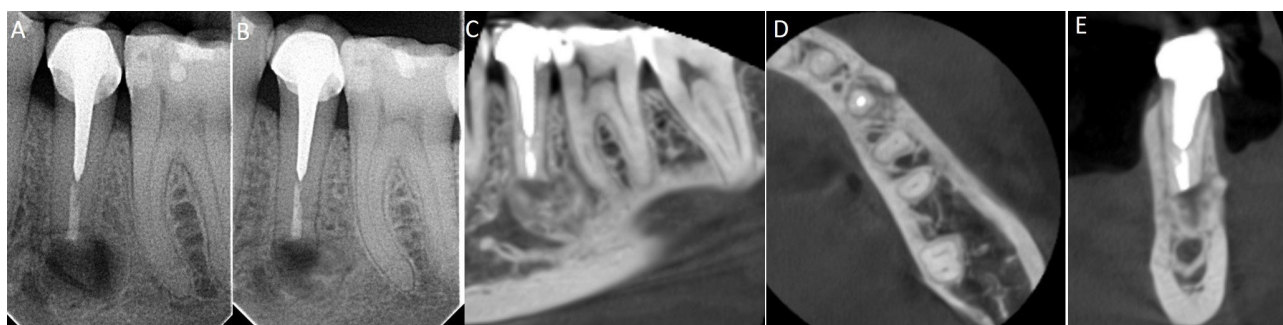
Periapical radiograph and CBCT follow-up of tooth #35. (A) post-surgical digital periapical radiograph showing apical filling material and cortical window in position. Five-month follow-up by (B) periapical radiograph and CBCT: (C) sagittal, (D) axial, and (E) coronal planes showed healing in progress.
